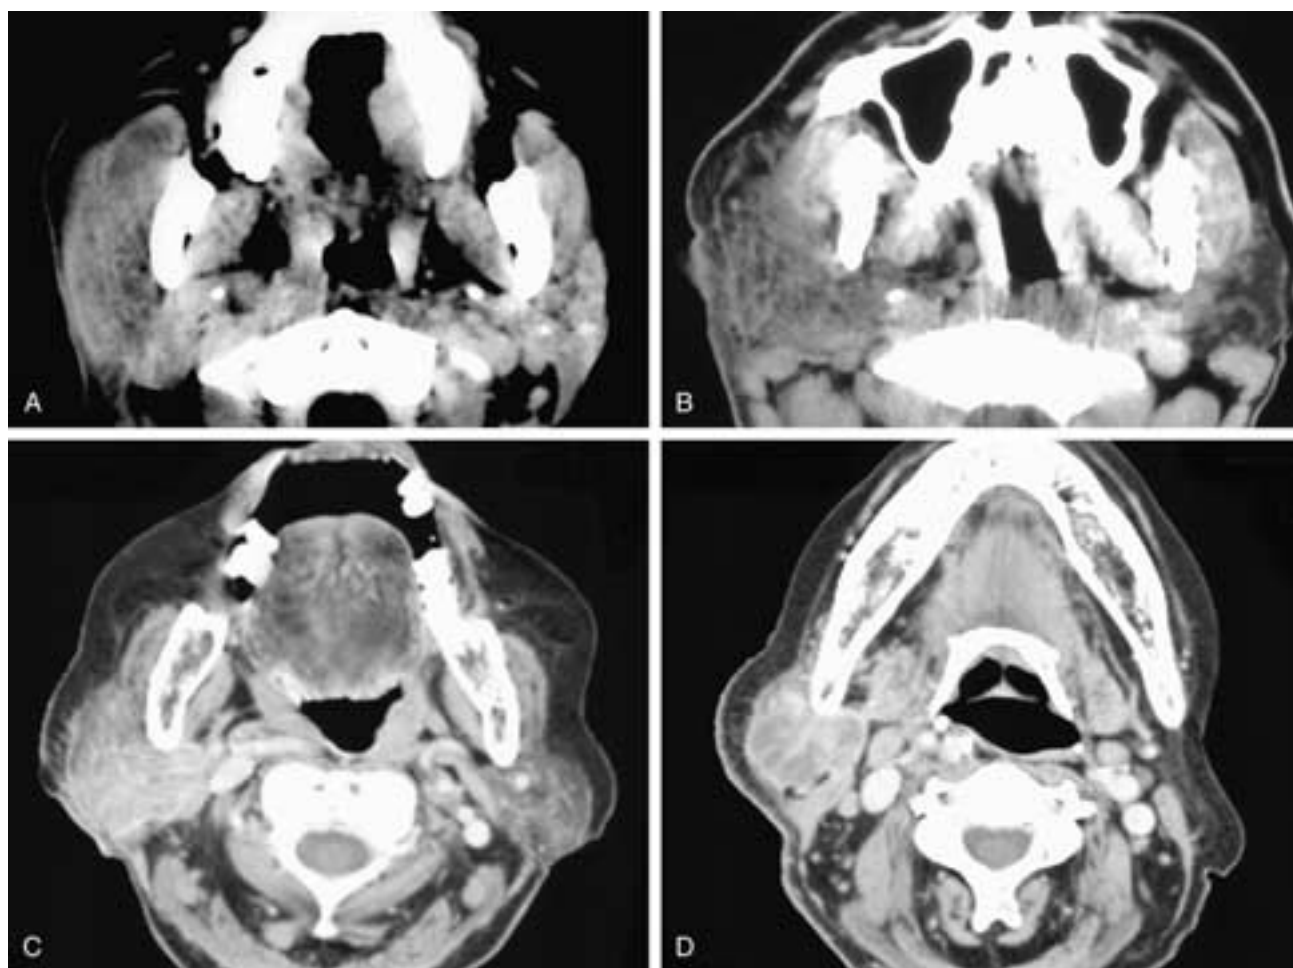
Axial contrast-enhanced CT scans on four different patients, all with acute sialadenitis. In A, there is enlargement of the right parotid gland, with blurring of the gland’s margins. The adjacent masseter muscle is also enlarged, and there is involvement of the overlying subcutaneous tissues and skin. Thickening of the central parotid duct can be identified. The left parotid gland is dense, and there are small calcifications in the peripheral ducts. These are changes of chronic sialadenitis. In B, there is diffuse enlargement of the right parotid gland with a myositis of the right masseter and internal pterygoid muscles and an associated cellulitis. In C, there is enlargement and enhancement of the right parotid gland with adjacent cellulitis. There is minimal involvement of the right masseter muscle. In D, the right parotid gland is swollen, and the dilated glandular lobules can be identified. There is also evidence of cellulitis.
